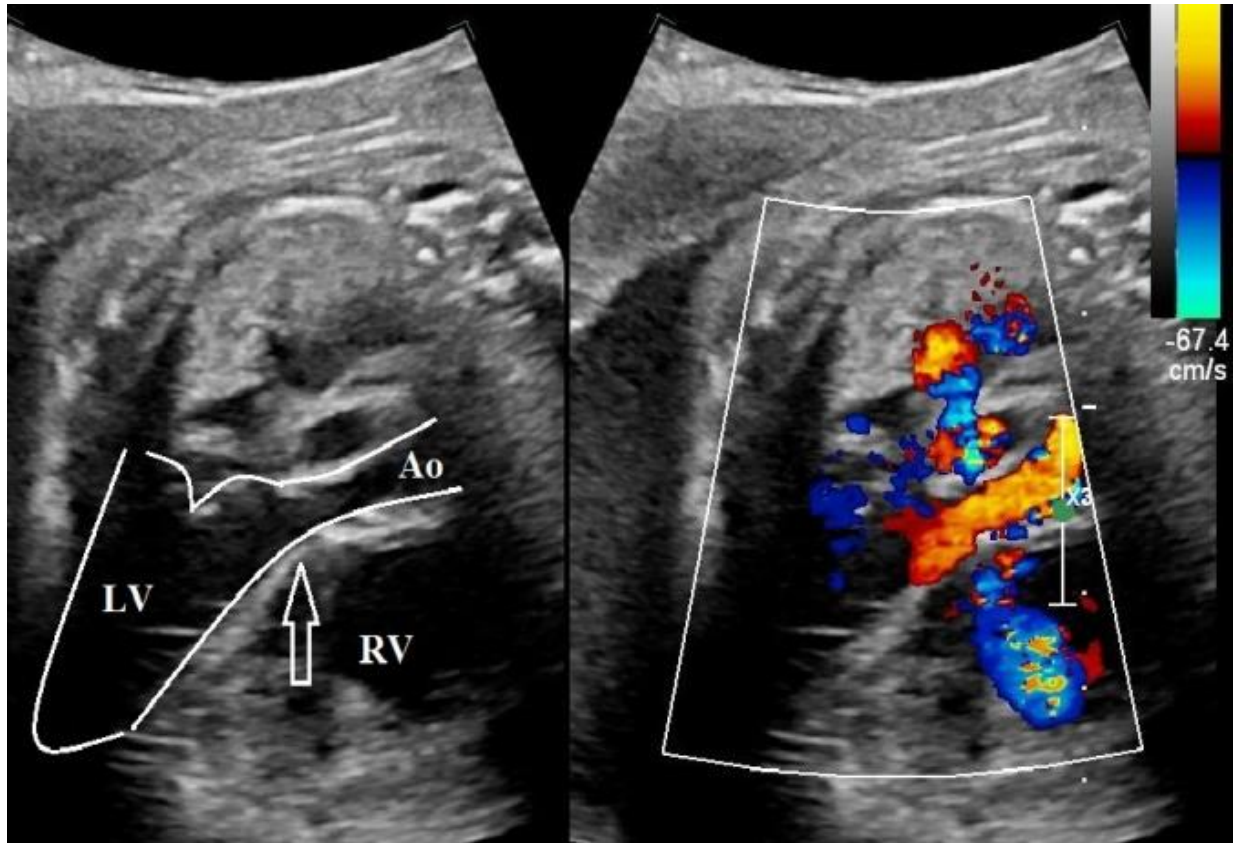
The same fetus of 31 weeks of gestation with APVS/IVS. On long-axis view of the LVOT, IVS (arrow) without any inter-ventricular shunt on color Doppler is visualized. (APVS, absent pulmonary valve syndrome; IVS, intact ventricular septum; LVOT, left ventricular outflow tract; LV, left ventricle; RV, right ventricle; Ao, aorta)
